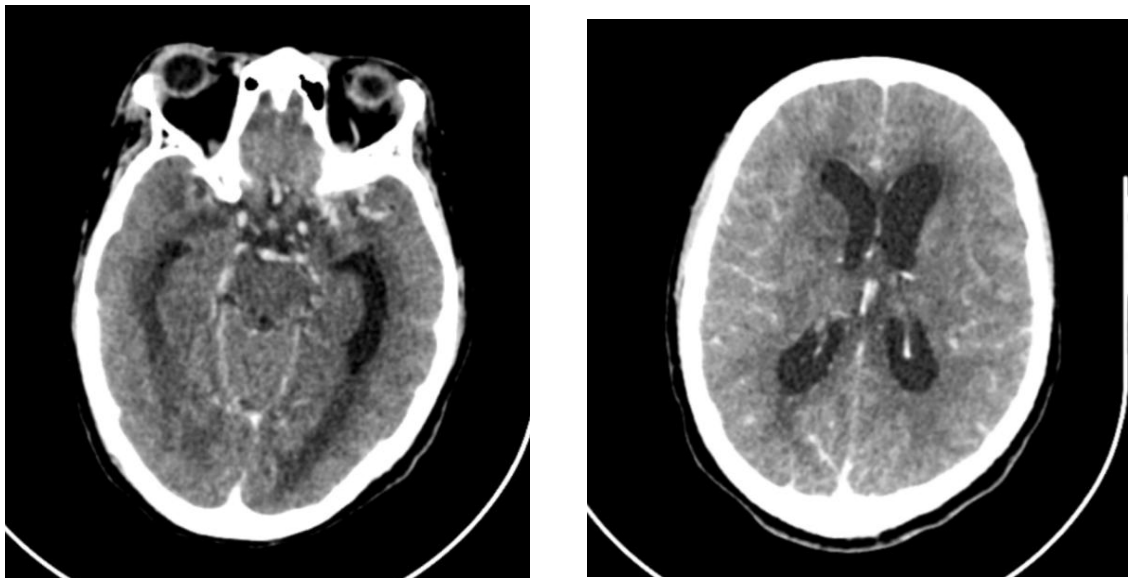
Post-contrast axial brain CT scans of a 30 year old male with limb weakness and headaches. Diffuse leptomeningeal enhancement is seen. The CT scan was acquired 4 days after the onset of symptoms.
